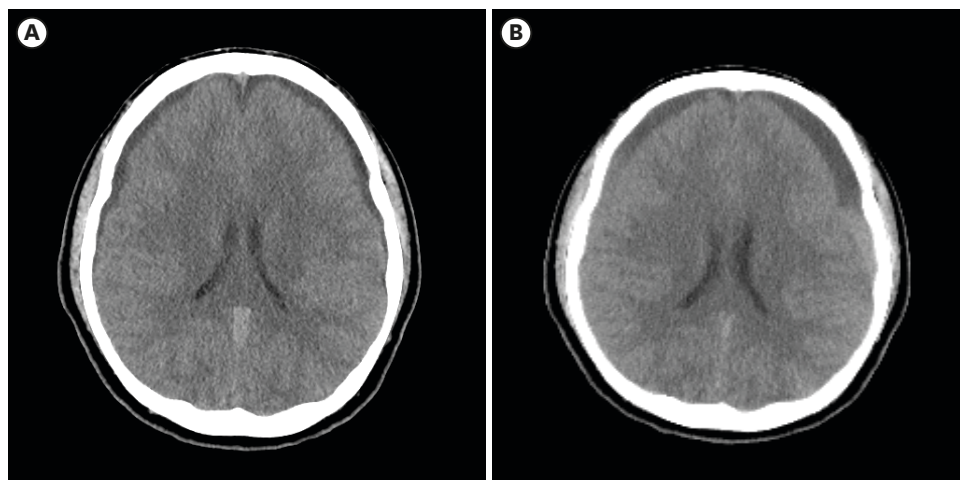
(A) On CT of week 1, bilateral subdural effusion was noted. (B) CT imaging after patient's mental deterioration 4 weeks after admission. Bilateral chronic subdural hematoma was compressing both lateral ventricles. CT: computed tomography.
